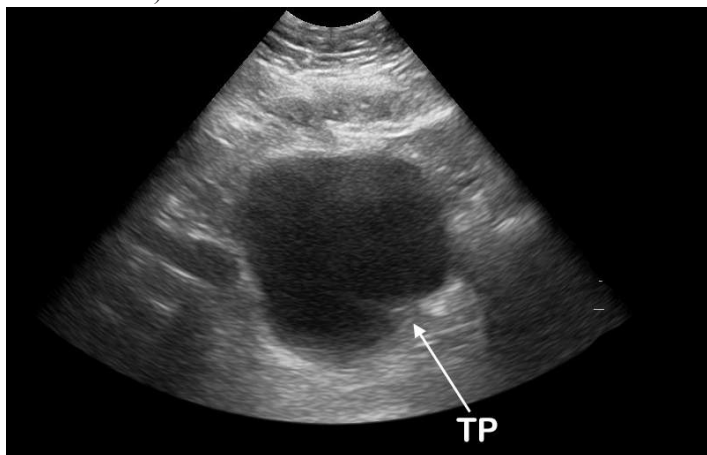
Emergency department ultrasound (EDUS). Thickening (T) and inward protrusion (P) at the left posterior bladder wall.
